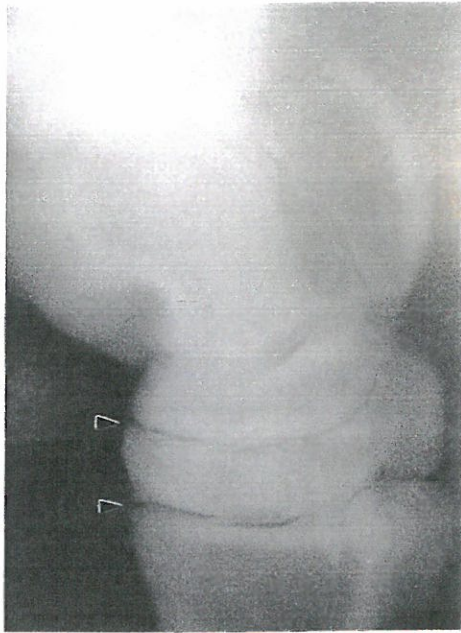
Radiograph of tarsal joints showing possible location of spavin in the Distal Intertarsal Joint and the Tarsometatarsal Joint.
